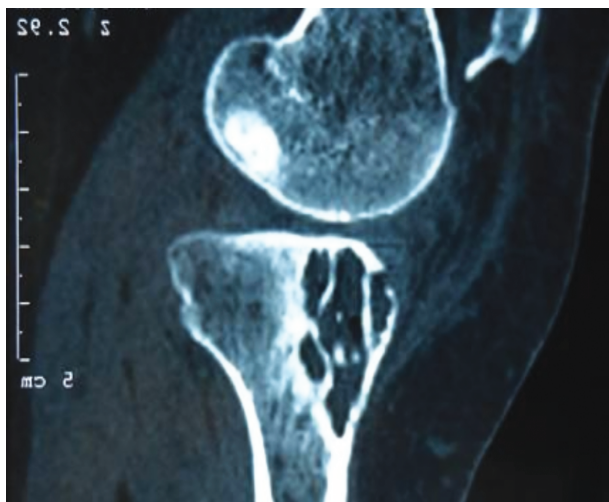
CT scan of the left knee showing a large cyst-like lesion with sclerotic margins in association with septum and air within the cystic lesion.
